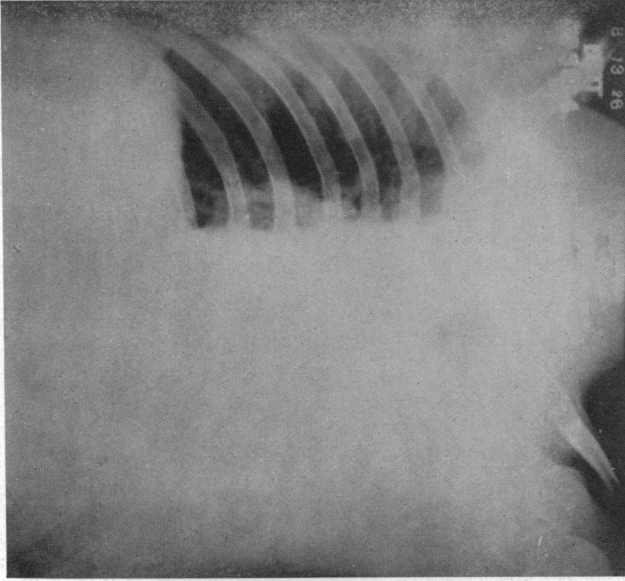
Twenty-four hours after first roentgenogram, showing marked increase in density.
